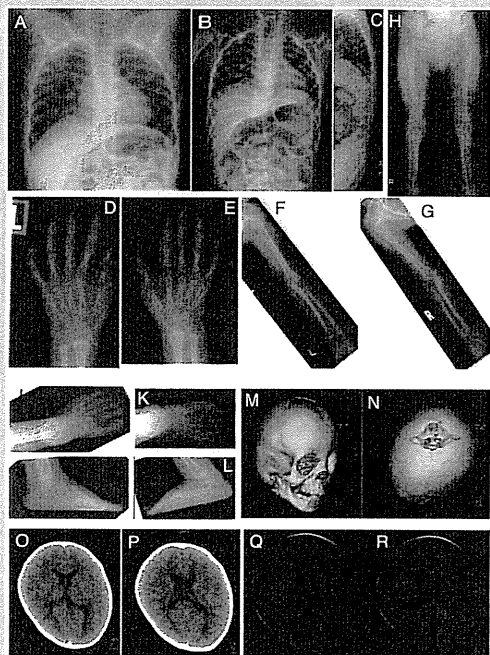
Radiographs of Patient 1 at age 1 year and 10 months (A) and 2 years and 6 months (B–L). Cranial and brain CT of Patient 1 at age 2 years and 6 months (M–P). Brain MRI of Patient 2 at age 1 year and 10 months (Q, R).
